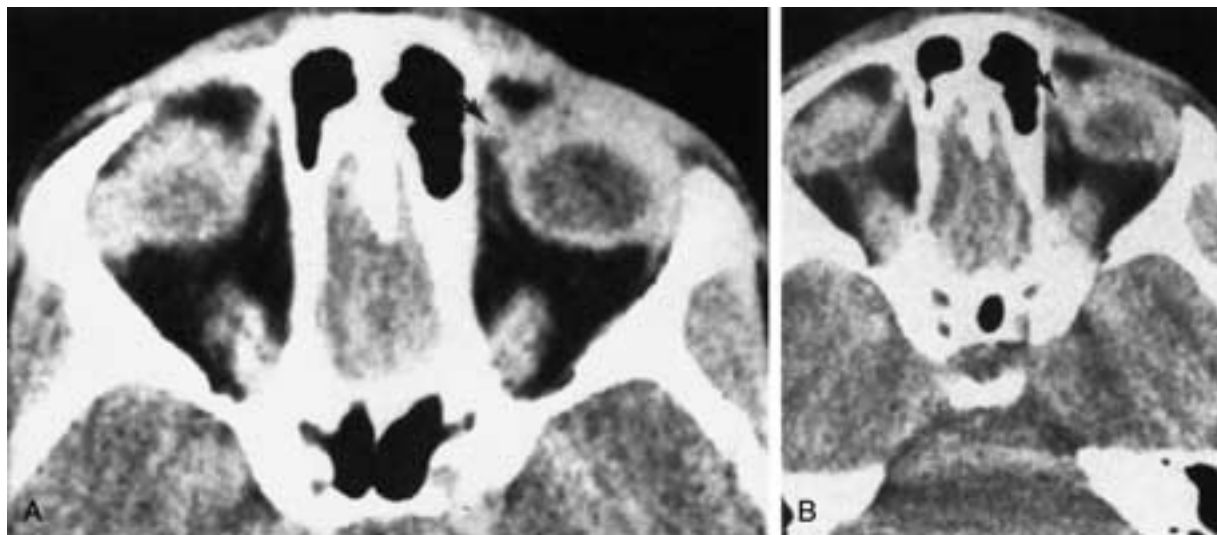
A, Axial CT scan demonstrates thickening of the reflected portion of the left superior oblique tendon (*arrow*). B, Scan taken 1.5 mm higher confirms the marked tendon thickening (*arrow*). (From Mafee MF, Folk ER, Langer BG, et al.: Computed tomography in the evaluation of Brown syndrome of the superior oblique tendon sheath. *Radiology* 1985;154:691–695.)
